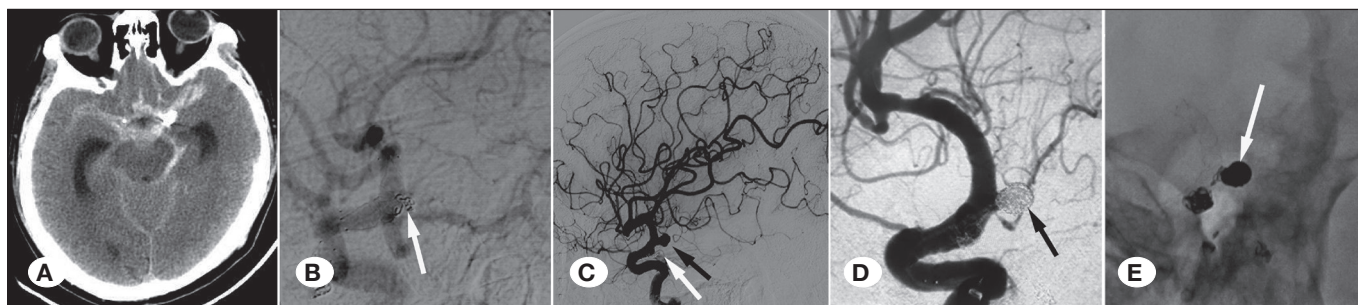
Images of the third procedure (March 2019). A) Brain CT indicated subarachnoid hemorrhage coupled with hydrocephalus. B) DSA revealed that the coils of the second treated aneurysm at the choroidal segment of the left ICA were in position. C) DSA revealed that the first treated aneurysm at the posterior communicating segment of the right ICA was stable (white arrow) and identified a newly developed pseudoaneurysm at the choroidal segment of the right ICA (black arrow). D, E) The postoperative DSA revealed complete occlusion of the aneurysm at the choroidal segment of the right ICA.
